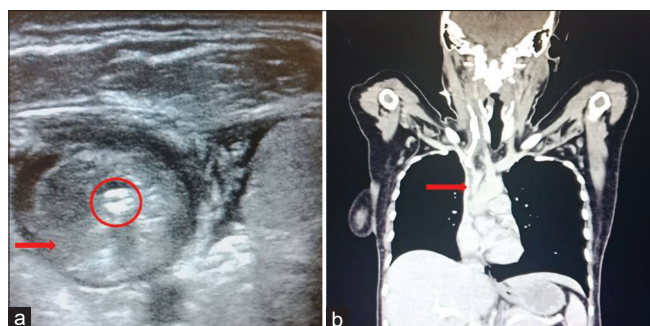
(a) Ultra sonogram (short-axis view) of right IJV showing thrombus (red arrow) engulfing the CVC (encircled). (b) CT venogram (coronal plane) showing the thrombus (red arrow) seen as filling defect extending upto proximal one-third of SVC
